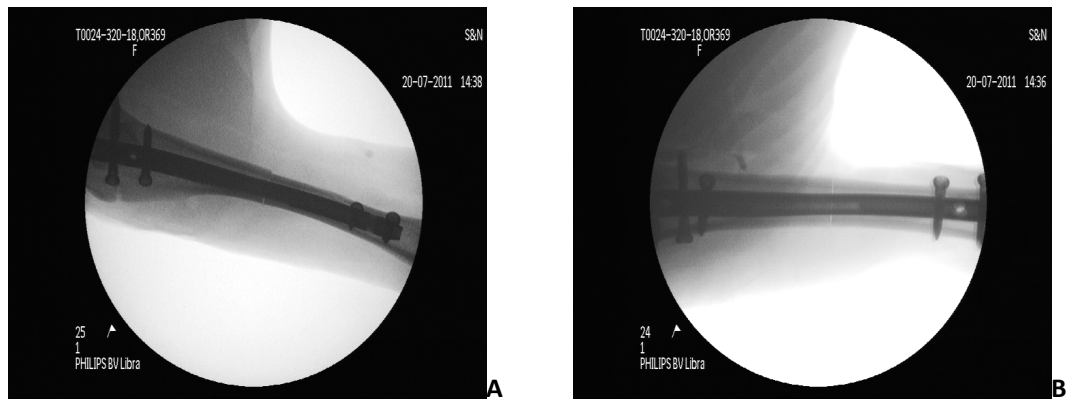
Digital X-ray images acquired immediately after surgery (A) lateral view, (B) A/P view
